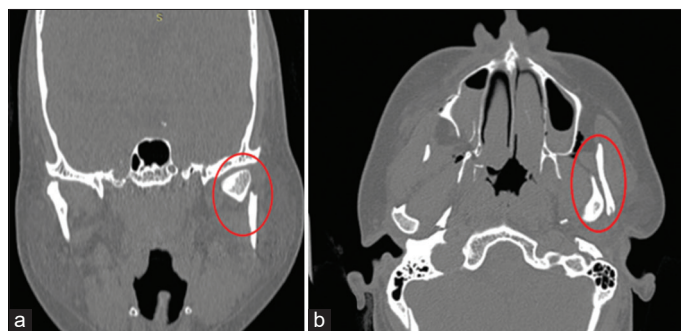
Computed tomography sections showing the condylar head fractures in (a) case 1 and (b) case 2
